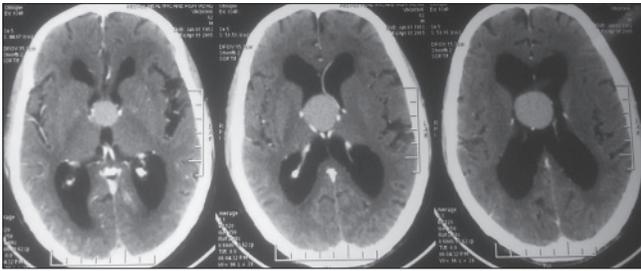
Contrast-enhanced computed tomography brain-S/O 3.2 cm x 2.8 cm giant non enhancing well-circumscribed hyperdense colloid cyst in third ventricle extending into lateral ventricles with obstructive hydrocephalus
